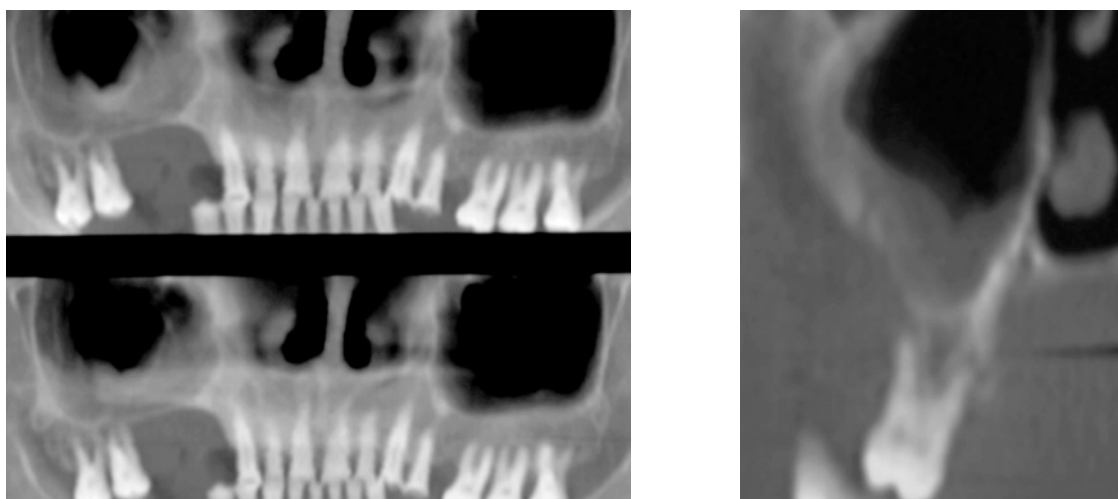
Plasmacytoma on reformatted panoramic (left) and cross-sectional (right) CT showing malignant pattern of bone destruction and resorption without expansion.
